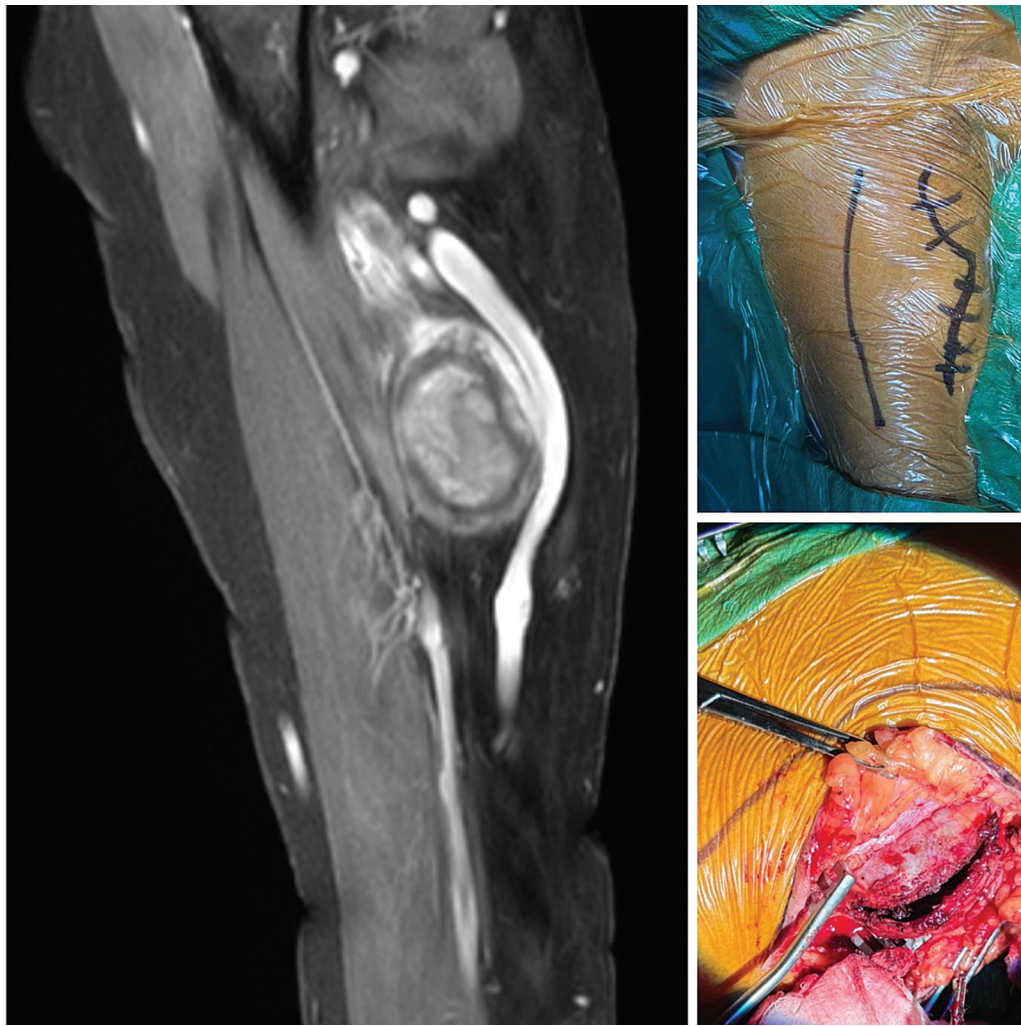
Contrast-enhanced magnetic resonance imaging (CE-MRI) demonstrates a right median nerve schwannoma (left image). The top-right image shows intraoperative marking for tumor excision, while the bottom-right image depicts the exposed tumor capsule following internal debulking.
